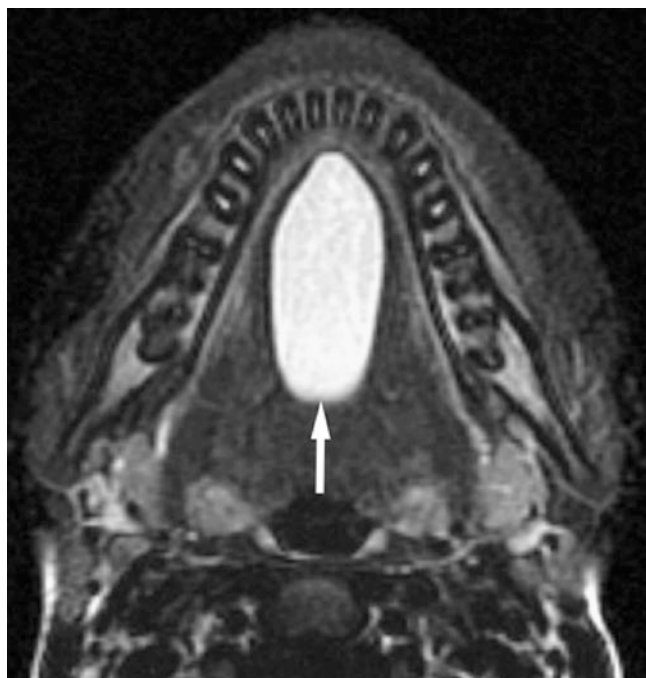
Dermoid cyst; 18-year-old male with doughy swelling of the floor of the mouth clinically considered a thyroglossal duct cyst. Axial T2-weighted fat-suppressed MRI shows well-defined oval mass with high signal in the floor of the mouth (*arrow*), located in sublingual space depressing mylohyoid muscle down (not shown)
